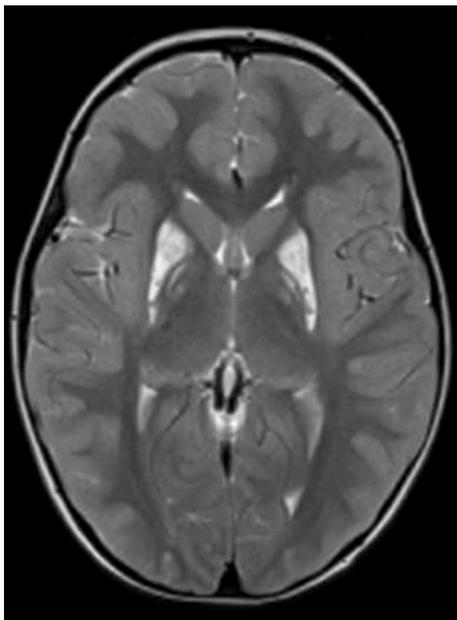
T2 supra-orbital MRI of a patient with Leigh syndrome due to the ND3 variant m.10134C > A showing symmetrical bilateral cystic gliosis within the globus pallidus (orange arrows). [reproduced from Miller et al. PlosOne 2014].
